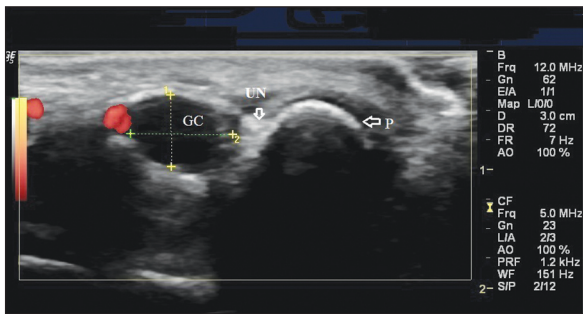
Ultrasonographic image of cyst before aspiration.
